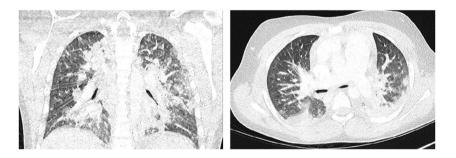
Lung window axial and coronal CT images of patient 3 that show diffuse bilateral consolidations predominantly located in the posterior aspects of the upper and inferior lobes. Images obtained from Dallan et al.¹⁷ The Lancet Child & Adolescent Health, Vol 4(7), E21-23 July 1, 2020, and permission to use granted by Elsevier License Terms and Conditions. CT, computed tomography
